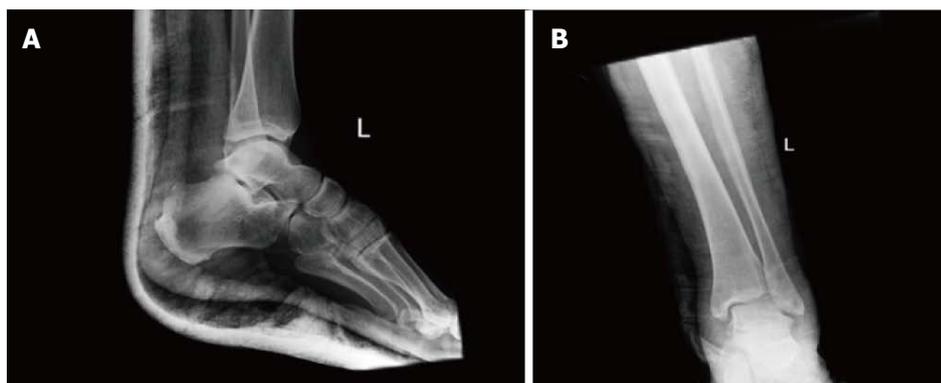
Radiographs of the left ankle after reduction and immobilization with a posterior splint. A: Lateral view; B: Anterior posterior view.
